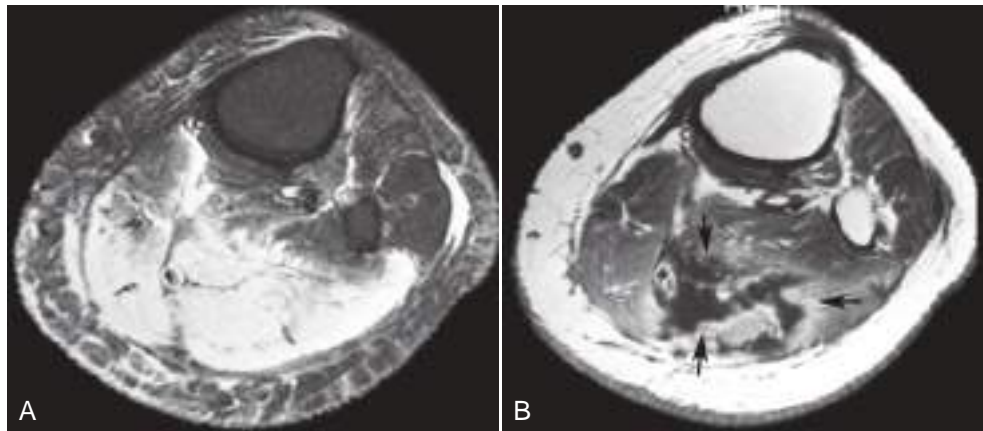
Diabetic myonecrosis. Axial fat-suppressed T2-weighted (A) and contrast-enhanced T1-weighted (B) MR images show intense edema in the left soleus in A and heterogeneous enhancement and an irregularly shaped muscle infarct (arrows in B). (Reprinted with permission from May DA, Disler DG, Jones EA, et al. Abnormal signal within skeletal muscle in magnetic resonance imaging: patterns, pearls, and pitfalls. *Radiographics*. 2000;20:S295-S315.)
